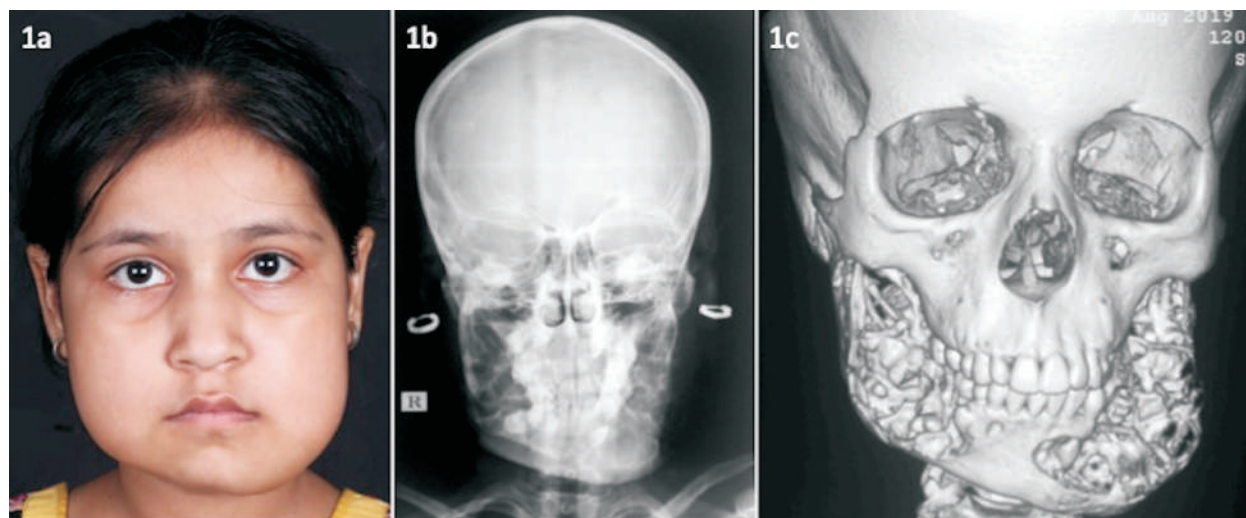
Cherubism characterized by (a) Bilateral fullness of the cheeks and jaws with slight upward tilting of the eyes, giving a 'cherubic' appearance; (b) Radiograph of the face showing multiple thin-walled cystic lesions involving rami and body of mandible; (c) Computed tomography of the face with 3D reconstructed images showing multiple expansile soft-tissue lesions involving both halves of the mandible causing areas of thinning and destruction of the overlying bony cortex.
